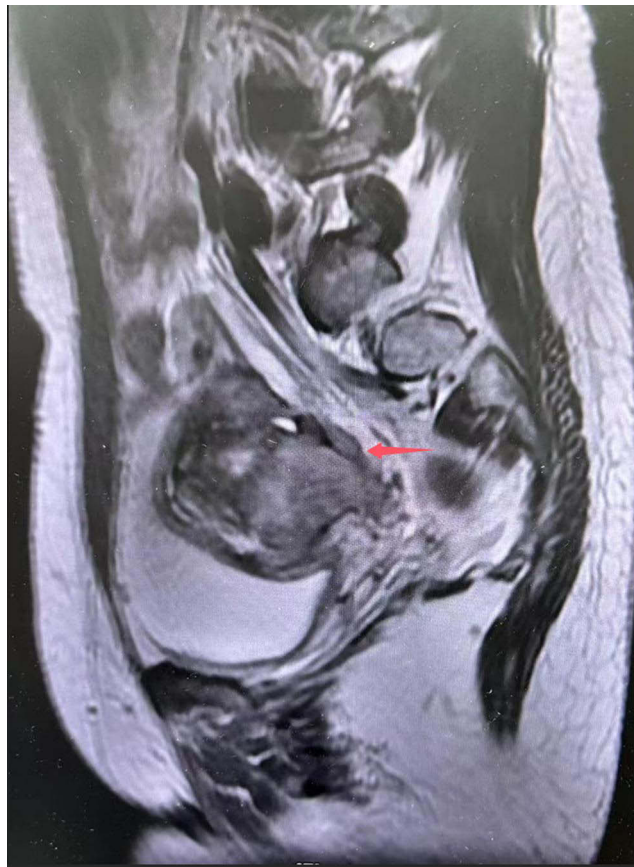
Pelvic MRI indicated that the nodules and masses in the pelvis were larger than before In February 2022. The red arrow denotes an increase in the size of the vaginal stump nodule relative to its dimensions in February 2022.
